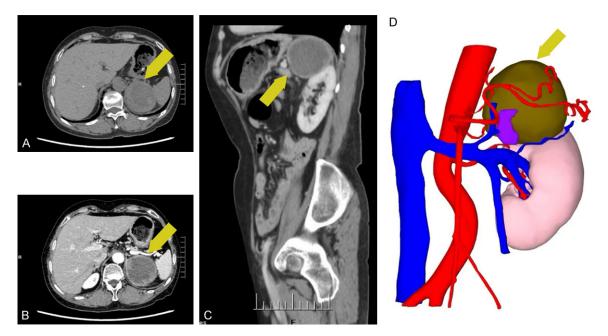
CT images and 3D printing model. A-C. A left-sided 6.5-cm pheochromocytoma in a 50-year-old man on CT scan. D. The corresponding 3D printing model. The tumor was indicated by yellow arrow.
